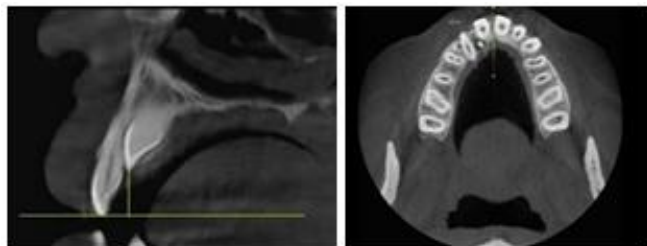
Sector classification done in axial view in CBCT using Alessandri's classification
